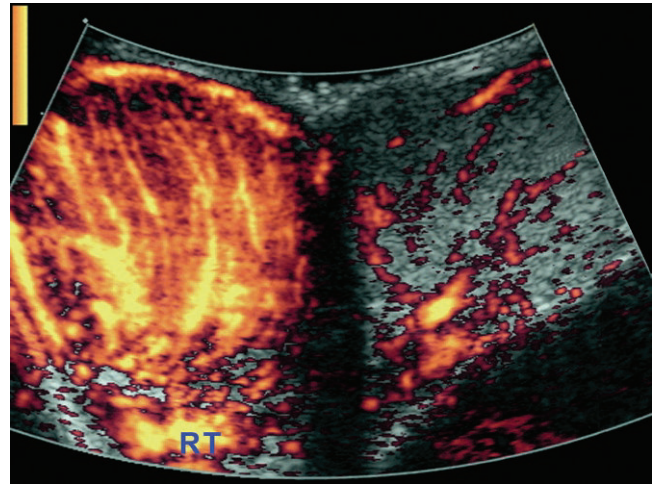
Hyperemia of right testis as noted on power Doppler. RT=right.
